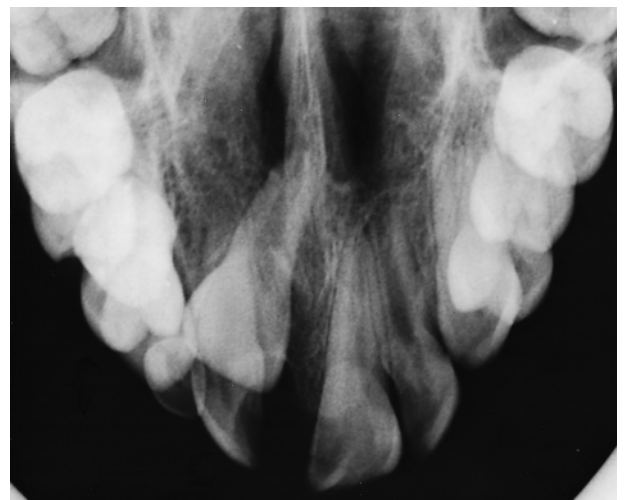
The maxillary occlusal radiographic view of the anterior maxilla after excision of the tumour.
